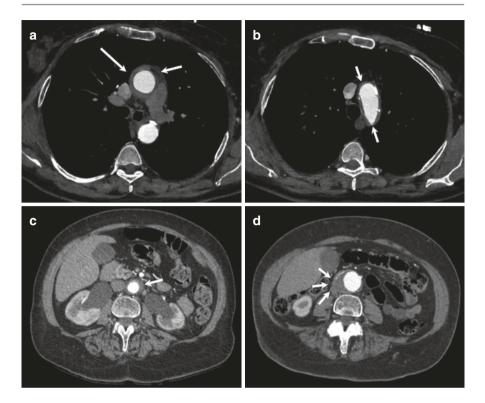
Computed tomographic (CT) appearance of aortitis and periaortitis. (a, b) Show CT images of a case of isolated thoracic aortitis. The scans (axial view) show aortic wall thickening involving the ascending aorta (a, arrows) and the aortic arch (b, arrows). (c, d) Show CT images of a case of abdominal periaortitis. The scans (axial view) show a periaortic tissue (c, arrow) and bilateral hydronephrosis (caused by ureteral involvement by periaortitis); the abdominal aorta is of normal caliber. In (d), a case of aneurysmal periaortitis is shown, where the periaortic tissue (arrows) surrounds an aneurysmal abdominal aorta
